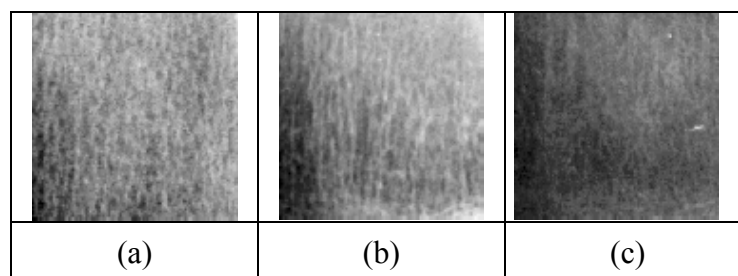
Sample X-ray images of bone tissue for different BMD coefficients
